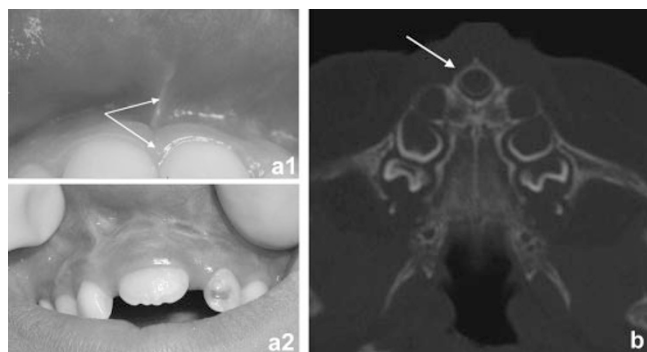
Solitary Median Maxillary Central Incisor (SMMCI) diagnosed by clinical and radiologic evaluation. (a1) Normal central dentition: note the frenulum labii superioris and the intermaxillary suture (arrows) (a2) SMMCI, absence of the frenulum labii superioris and of the intermaxillary suture. (b) Axial Computed Tomography slice at the level of the maxillary bone demonstrating a SMMCI (arrow).
